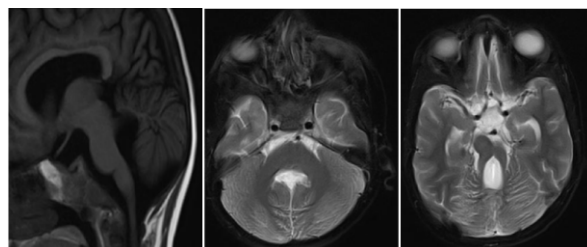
A, T1-weighted sagittal MRI depicting thick superior cerebellar peduncle oriented perpendicular to the posterior aspect of the brain stem. Dilated fourth ventricle with concavity of the roof.
